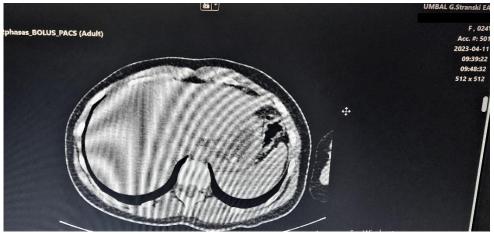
Follow –up Abdominal CT with contrast shows no liver metastases.
